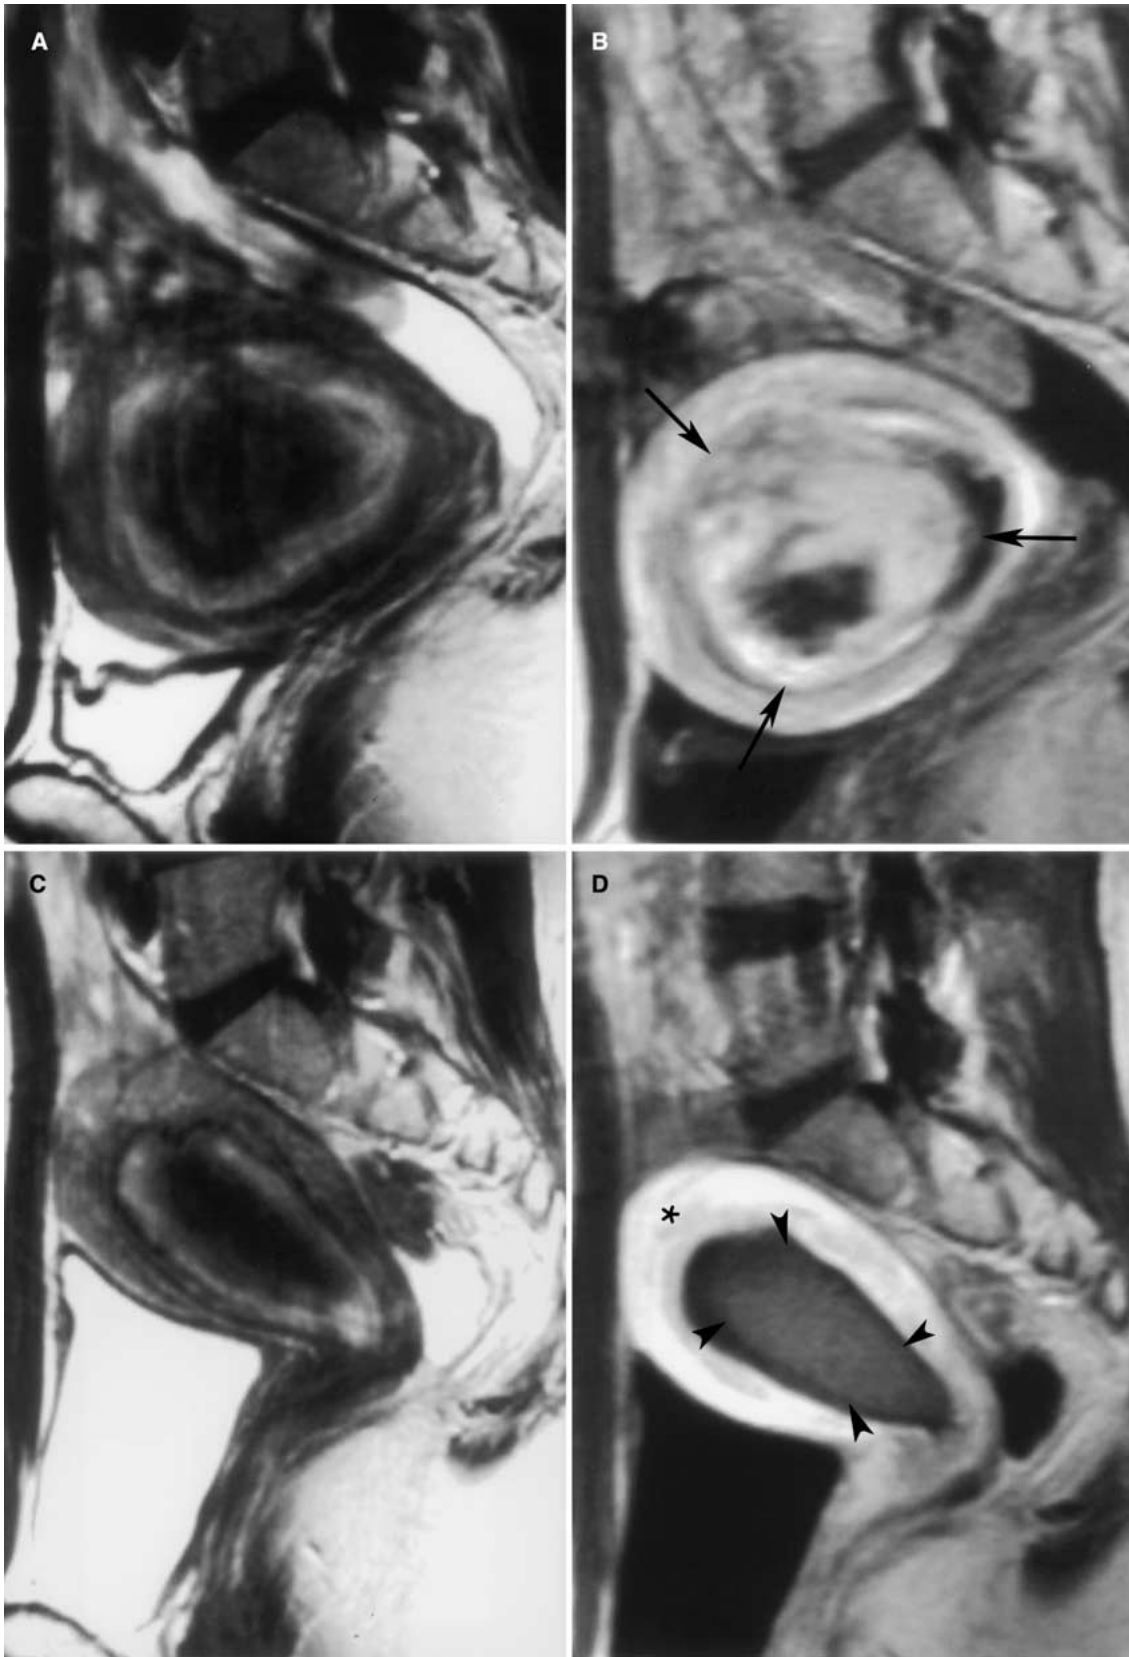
Patient no. 3 was a 30-year-old woman with submucosal myoma. (A) T2-weighted sagittal MR image and (B) gadolinium-enhanced T1-weighted MR image show a well-enhancing submucosal myoma (7 cm) (arrows). (C) T2-weighted and (D) gadolinium-enhanced T1-weighted MR images at follow-up 3 months after UFE reveal volume
